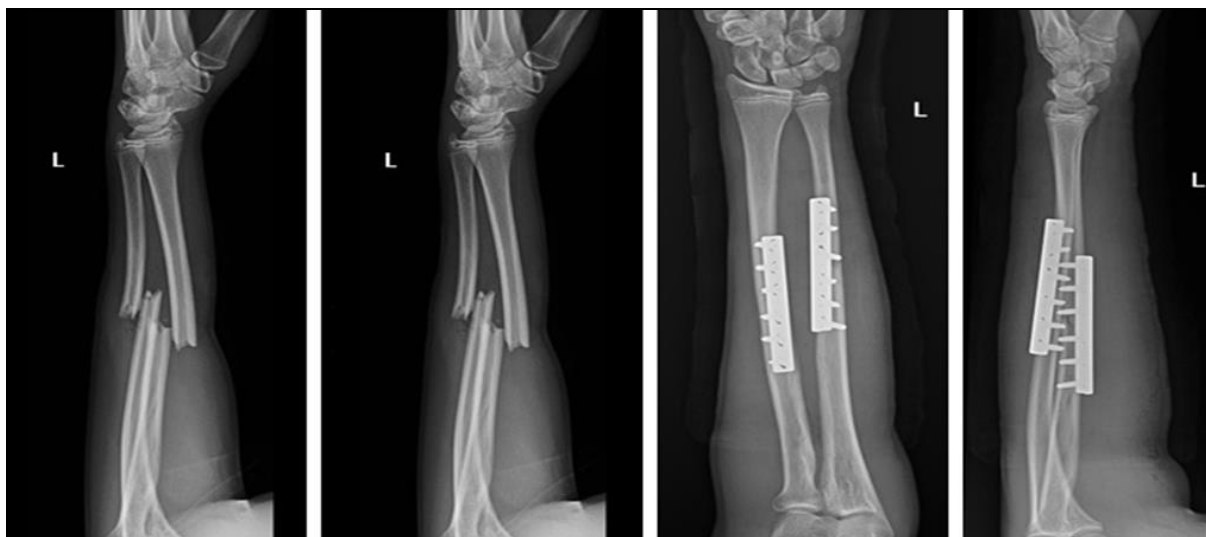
Preoperative (a, b) and postoperative (c, d) radiographs of the fracture radius and ulna
